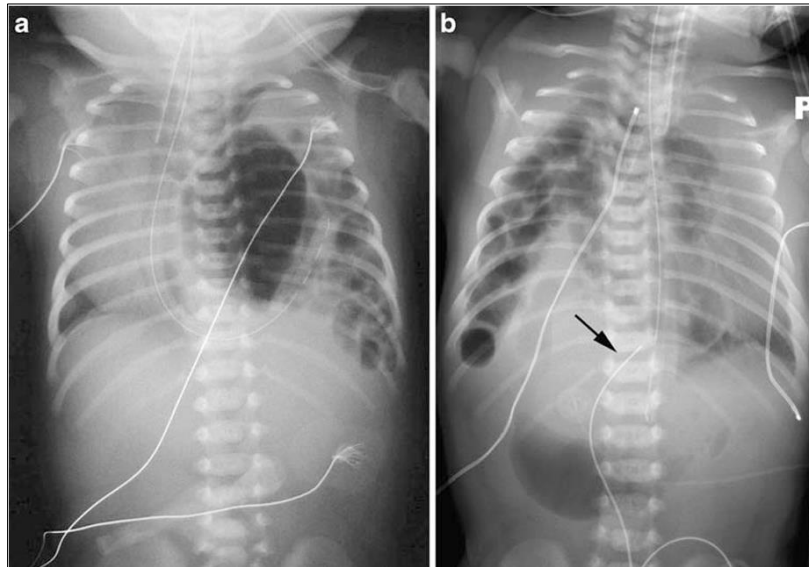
Neonatal Bochdalek hernia. a A 1-day-old boy with left Bochdalek hernia. Chest radiograph shows deviation of the endotracheal tube and esophageal portion of the nasogastric tube to the right. Intra thoracic displacement of the nasogastric tube tip, bowel and stomach confirm the diagnosis of diaphragmatic hernia. b A 2 day-old girl with right Bochdalek hernia. Chest radiograph shows deviation of the nasogastric tube and umbilical venous catheter (arrow) to the left
